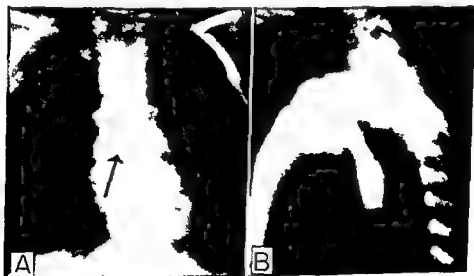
Roentgenograms of a nonopaque obstructing foreign body in the esophagus. The object is a nut lodged in the thoracic segment. The barium mixture outlines the superior surface of the object (Chevalier Jackson Bronchoscopic Clinic)
